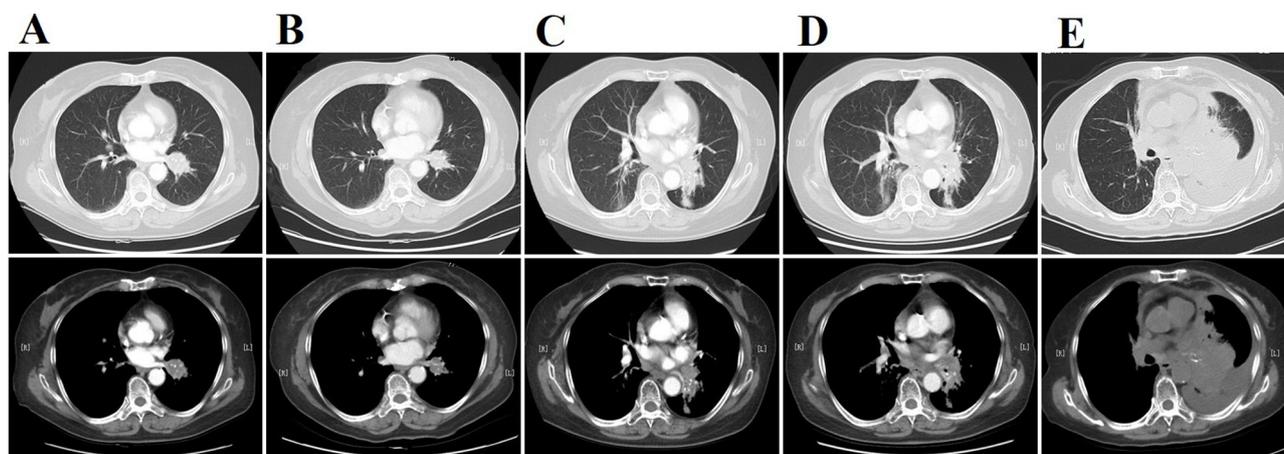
Computed tomography (CT) scans for case 32. The chest CT showed changes in the primary lung carcinoma (A), after the first-line chemotherapy (B), a month later with crizotinib treatment (C), 4 months later with crizotinib treatment (D), and 8 months later with crizotinib treatment with enlargement of the pulmonary consolidation (E). The response to crizotinib was evaluated as progressive disease (PD).
